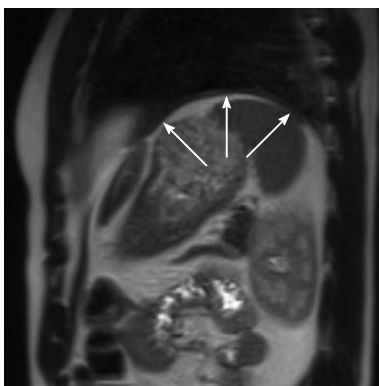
Magnetic resonance imaging appearance of the diaphragm. This TSE T2-weighted sagittal image shows the left hemidiaphragm as an uniformly thin intermediate signal intensity band (arrows) between lung parenchyma and intra-abdominal fat.
